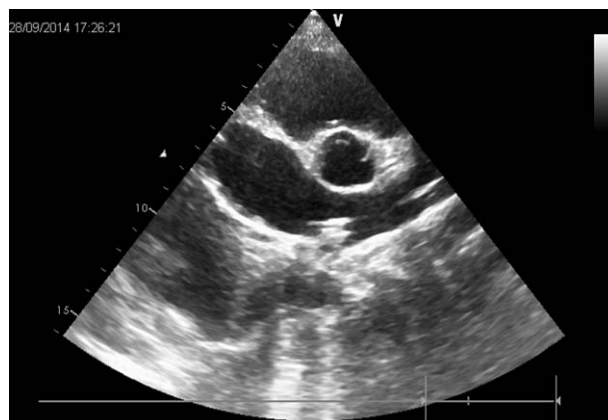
A guidewire was inserted into the left atrium (parasternal short-axis view).
